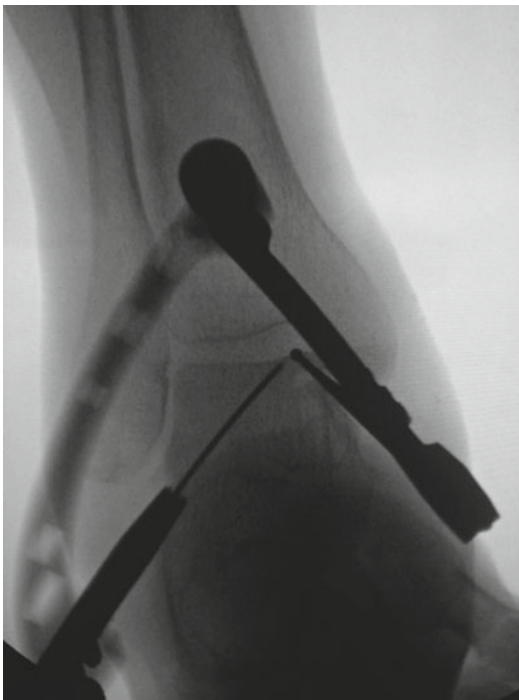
Intraoperative anteroposterior ankle x-ray showing passage of the guide wire through the aiming device. The guide wire is positioned accurately within the osteochondral lesion, abutting against but not perforating through the subchondral bone
